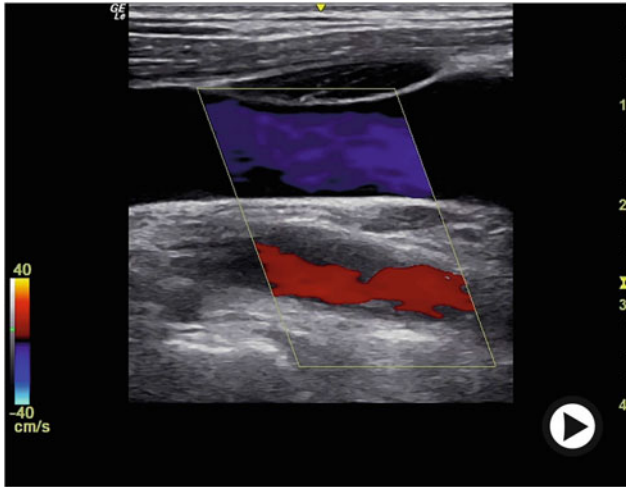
(Video 3.1) A video loop showing a scan obtained with the transducer positioned laterally on the neck with the probe marker pointed cephalad (toward the head). This approximate coronal plane allowed visualization of both the RCCA and RIJV. The RCCA is the deeper of the two vessels on this loop. Note that the Doppler sample box is angled in such a manner that the transmitted ultrasound beam travels left to right on the screen as it moves deeper. The red color within the RCCA indicate flow is moving from right to left on the screen toward the transmitted ultrasound beam. The blue color within the RIJV indicates flow is moving left to right on the screen away from the transmitted beam (► <https://doi.org/10.1007/000-7pk>)
